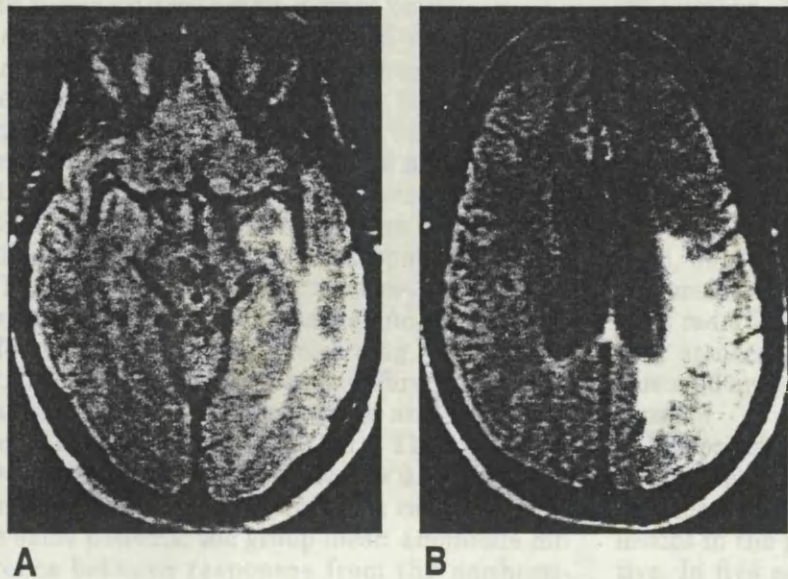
(Case 15) T_2 -weighted MR images. (A and B) A very extensive high-signal area extends from the temporal and occipital lobes (A) to the parietal lobe (B).
